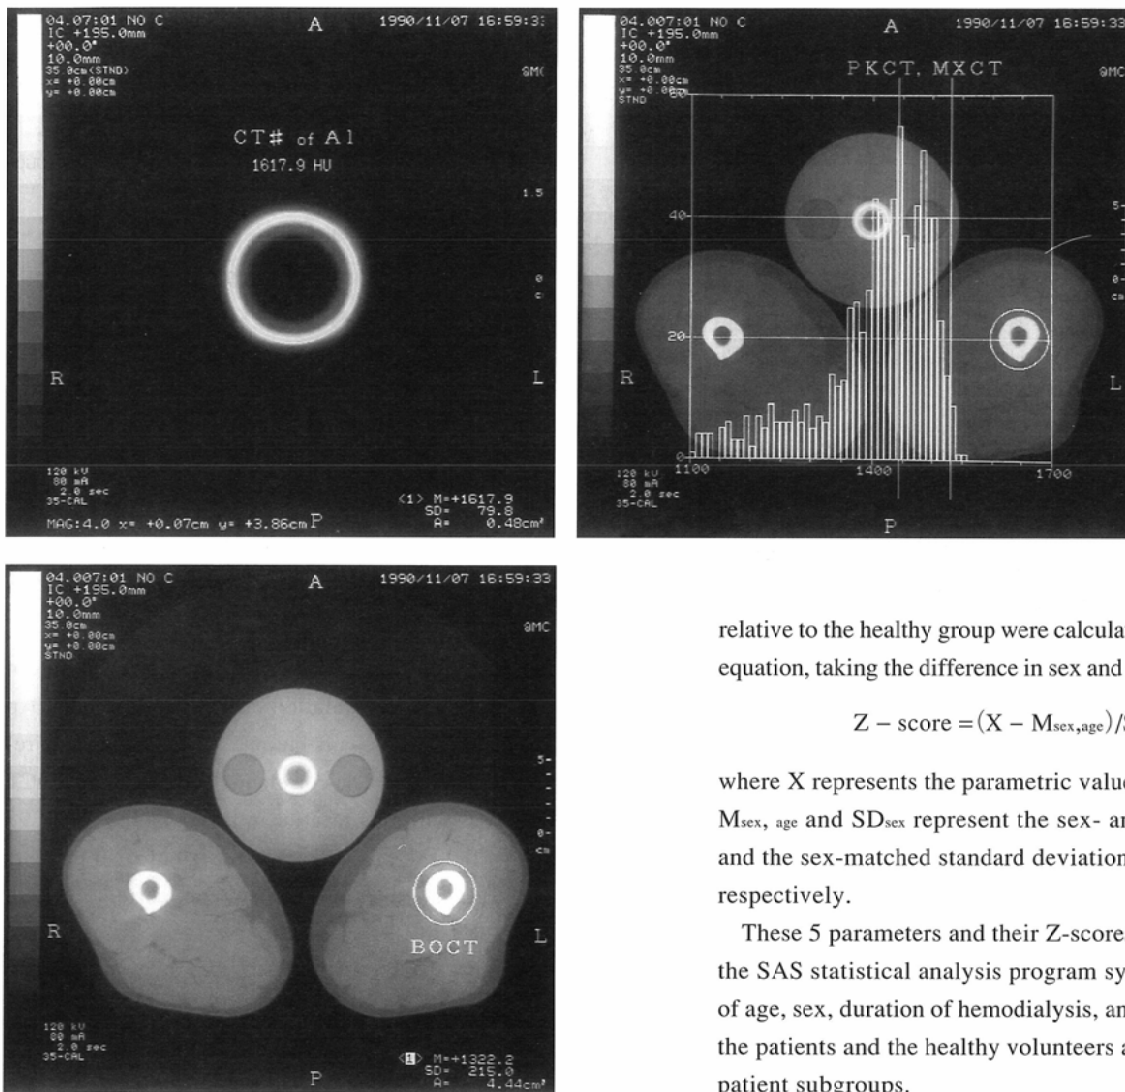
Extraction of the CT numbers of cortical bone in the femoral shaft (refer to Table 3). (A)ALCT, aluminum CT number; (B) BOCT, bone CT number; and (C) PKCT, peak CT number, and MXCT, maximum CT number.
